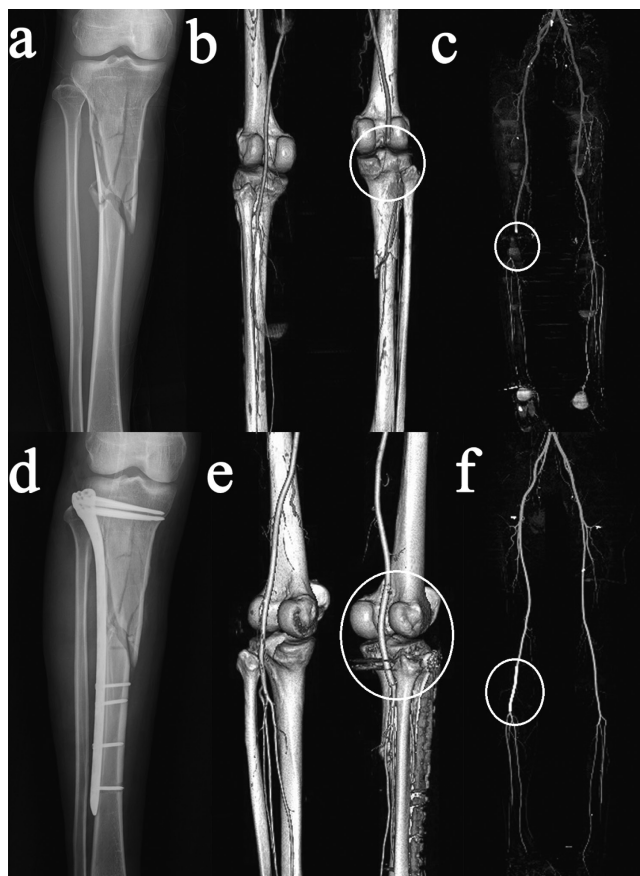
Radiography and CTA of a 50-year-old man. (A) Radiograph showed a comminuted fracture of the upper right tibia. (B, C) CTA scan revealed occlusion of the right popliteal artery. (D) Radiograph showed internal fixation of the upper right tibia fracture with a locking plate. (E, F) The postoperative CTA scan demonstrated that a stent was seen in the right popliteal artery, and the blood flow was unobstructed. CTA = computed tomography angiography.
